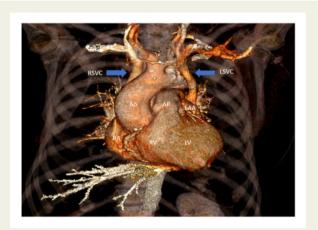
A three-dimensional reconstruction of a cardiac computed tomography scan clearly showing a double superior vena cava. Ao, aorta; AP, pulmonary artery; LAA, left atrial appendage; LSVC, left superior vena cava; LV, left ventricle; RA, right atrium; RSVC, right superior vena cava; RV, right ventricle.
